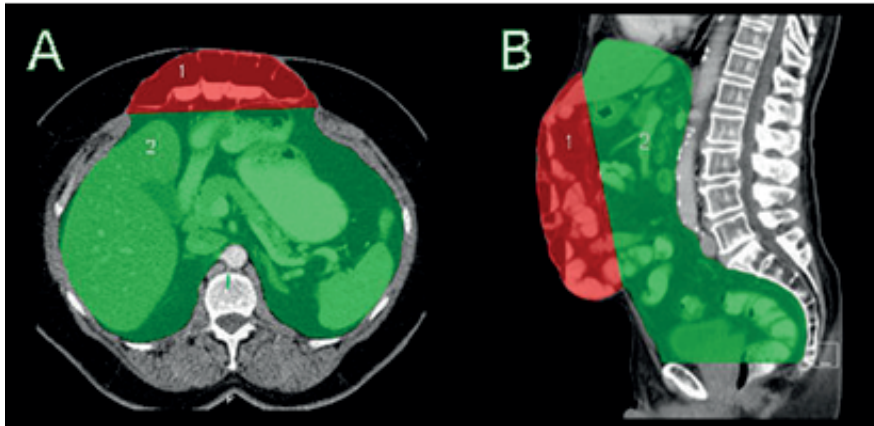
CT-outlining of hernia sac (HSV) and abdominal cavity volume (ACV). (A) transversal slide showing CT-outlined hernia volume (1/red) and intraperitoneal space (2/green). (B) Sagittal slide showing hernia volume and abdominal cavity volume with caudal limit over the pubic symphysis.
